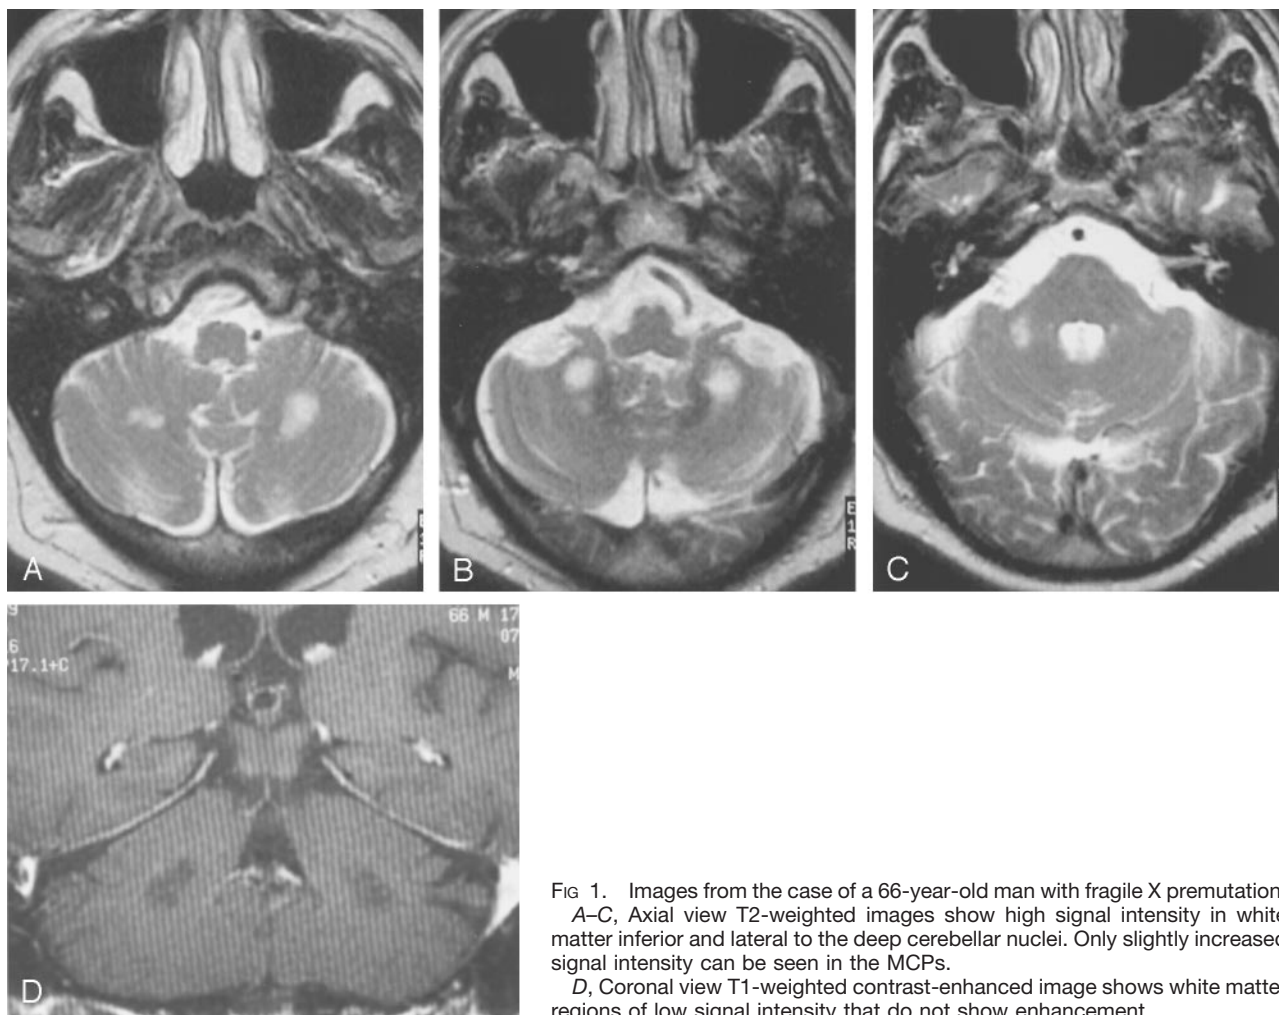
Images from the case of a 66-year-old man with fragile X premutation. A–C, Axial view T2-weighted images show high signal intensity in white matter inferior and lateral to the deep cerebellar nuclei. Only slightly increased signal intensity can be seen in the MCPs. D, Coronal view T1-weighted contrast-enhanced image shows white matter regions of low signal intensity that do not show enhancement.
